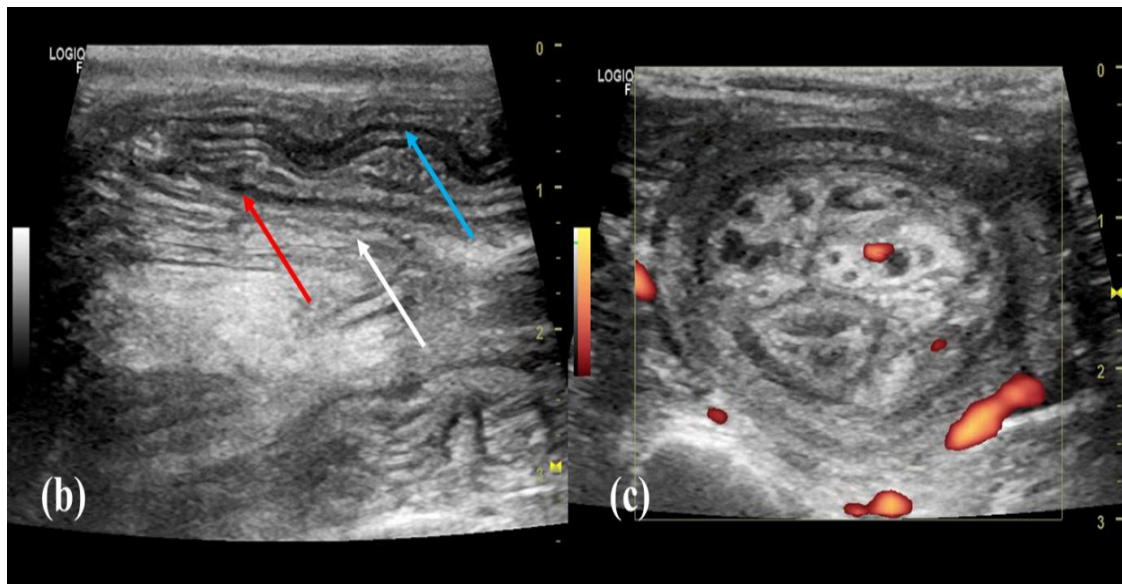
Abdominal ultrasonography in transverse view (a) and longitudinal view (b) demonstrating the characteristic triple-circle (or triple-target) sign diagnostic of double intussusception. The white arrow indicates the innermost circle (intussusceptum), the red arrow denotes the middle circle (first intussusciens), and the blue arrow represents the outermost circle [second or 'parent' intussusciens]. (c) Power Doppler image confirming vascular supply within the involved segments, suggestive of intestinal viability
